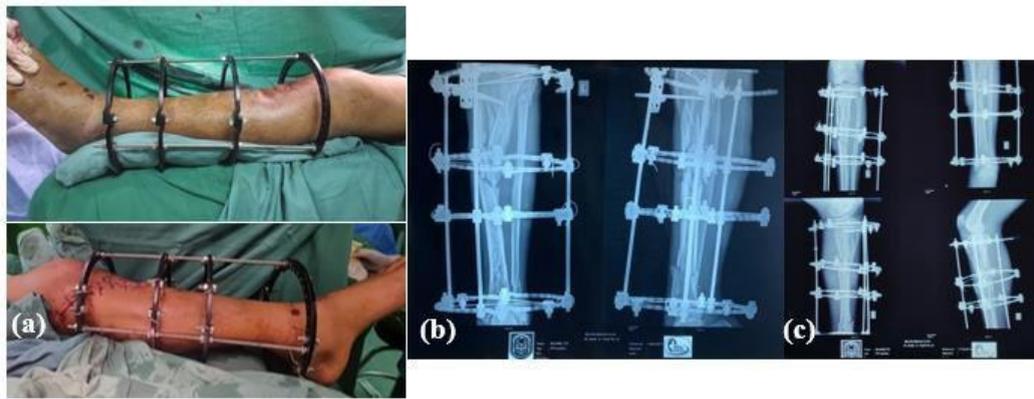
(a) The post operative clinical picture and (b) Post-surgical X-Ray of the patient's tibia-fibula, (c) One months evaluation X-Ray post-surgery
